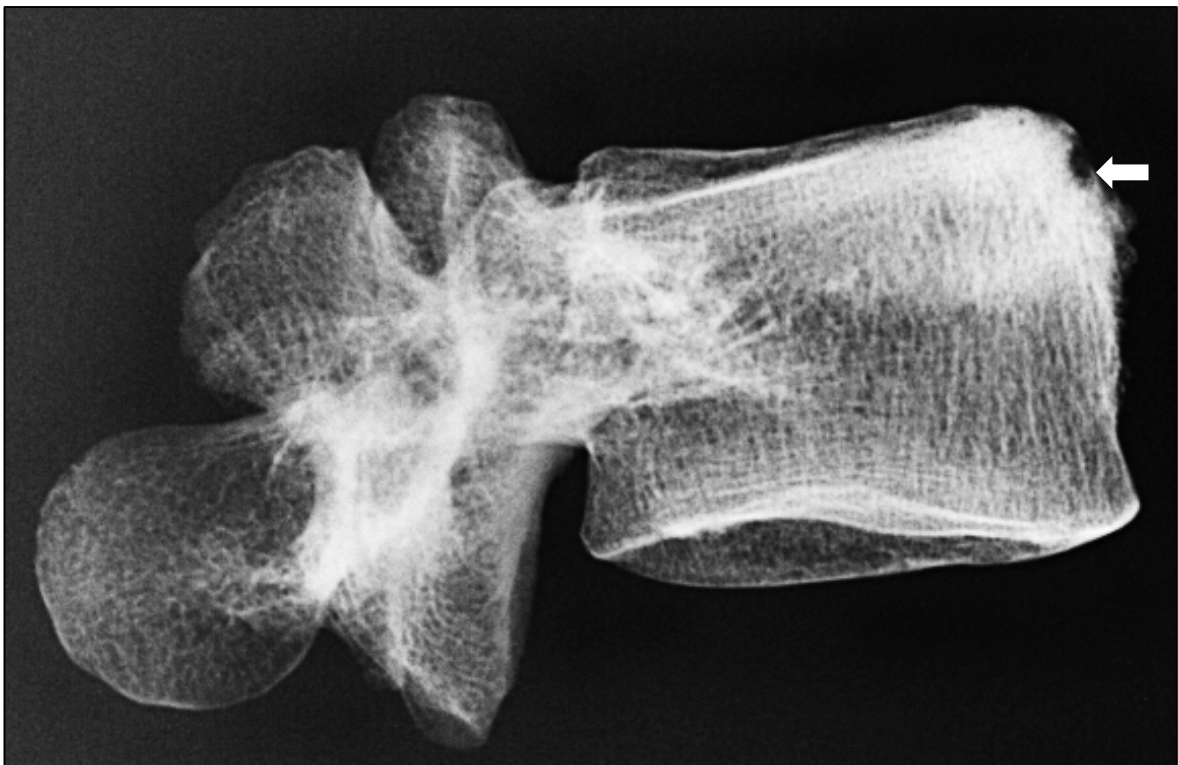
Radiographic sign suggestive for brucellosis. Note the “parrot’s beak” formation on the superior margin associated with osteolytic destruction (AT-2, young adult female, Naimaa Tolgoi). Image: author’s own.
